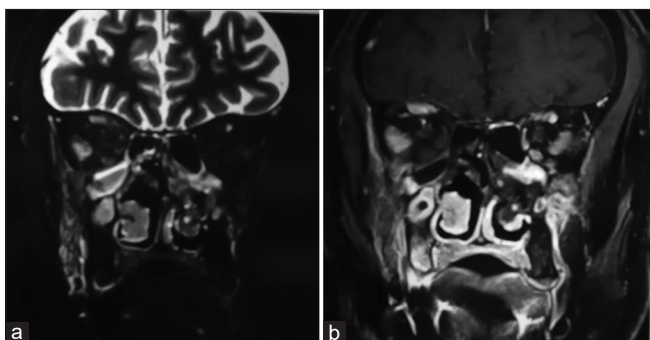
(a) MRI image of human skull infected due to fungi infection. (b) MRI image of human facial bones [1]
